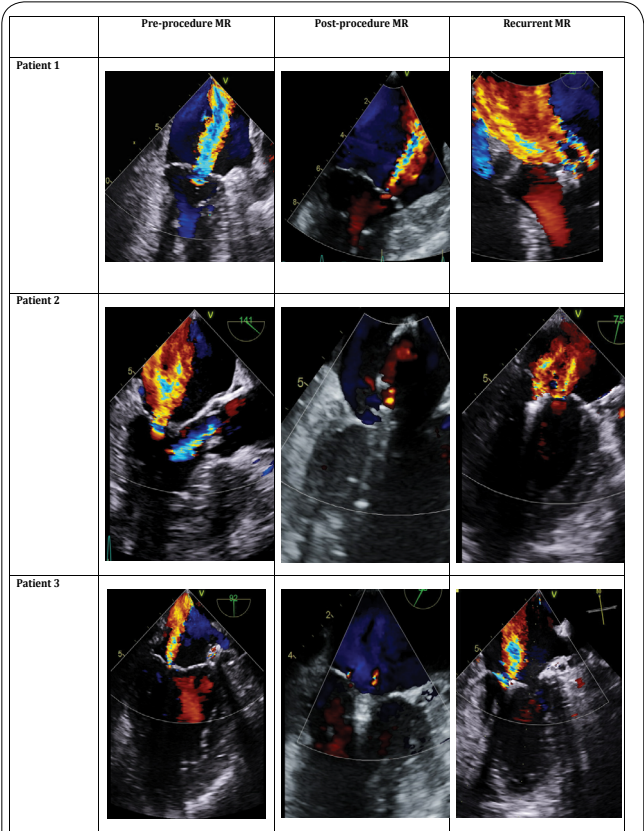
Two-dimensional transesophageal echocardiogram imaging in the mid-esophageal window of patient 1 (top), patient 2 (middle), and patient 3 (bottom) showing pre-procedural (left), post-procedural (middle), and recurrent MR (right).
